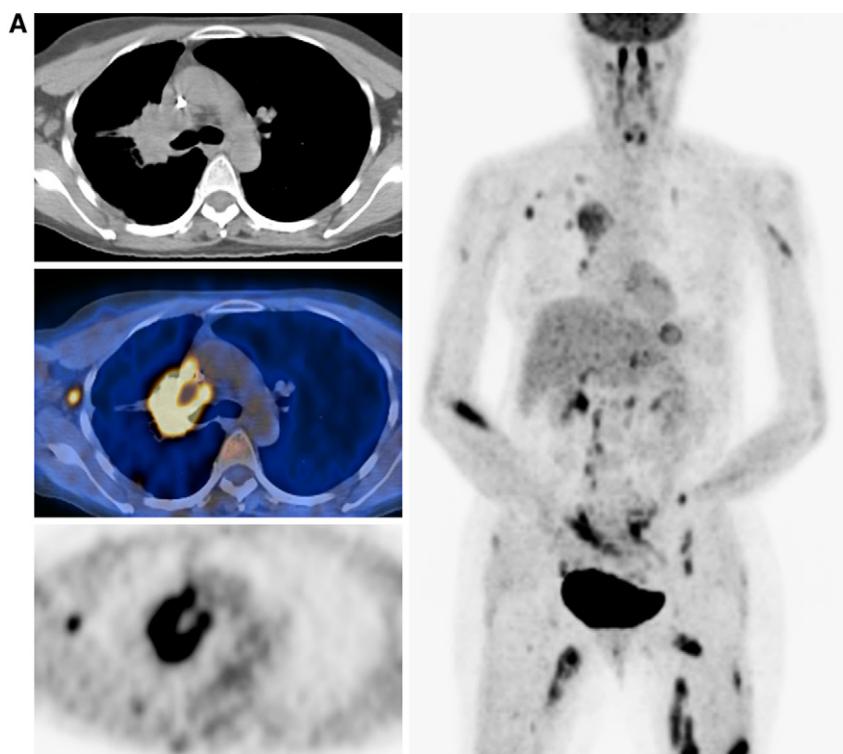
A 54-year-old woman with adenocarcinoma of the right lung. (A) FDG-PET showed increased uptake in the right hilar mass. Whole body maximum intensity projection image demonstrates extensive nodal metastases in the chest and abdomen. (B) Note musculoskeletal metastases in the legs.
